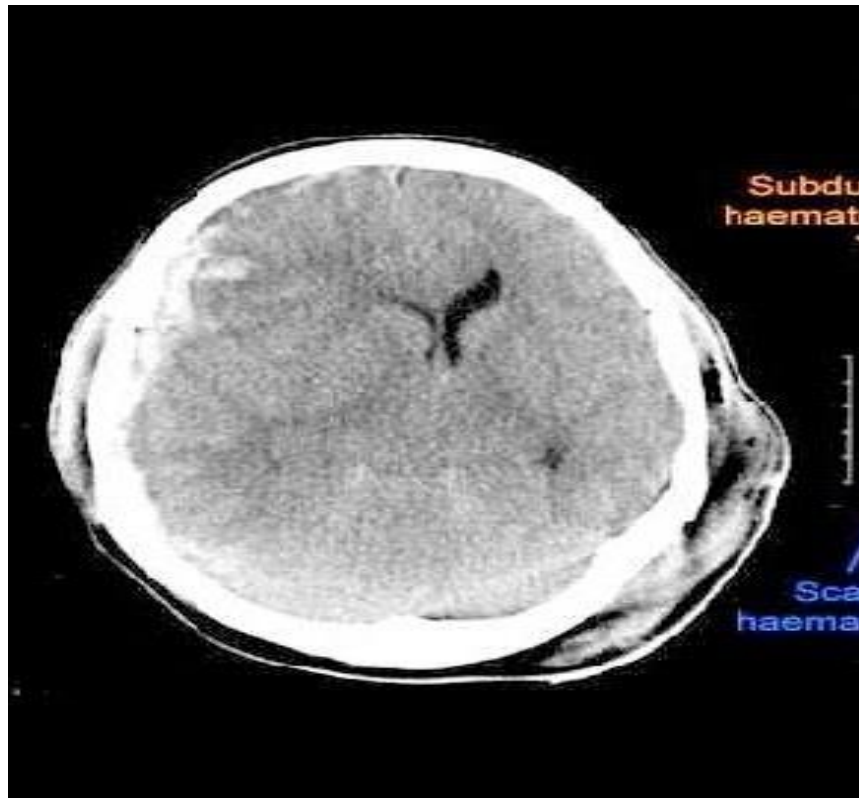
CT image shows the traumatic disorder causes subdural hematoma.
